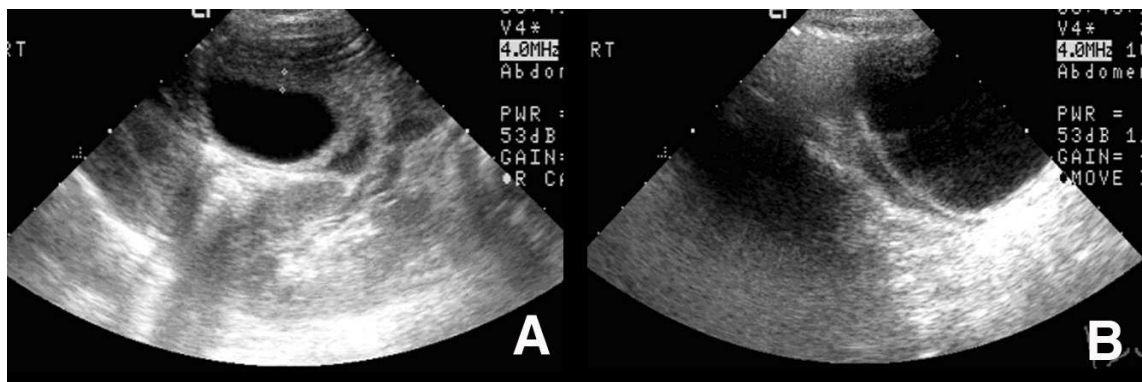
Abdominal ultrasonography of a 5-year-old male with infectious mononucleosis. A. Ultrasonography shows diffuse gallbladder wall thickening. B. Fluid collection is noted in pelvic cavity.
